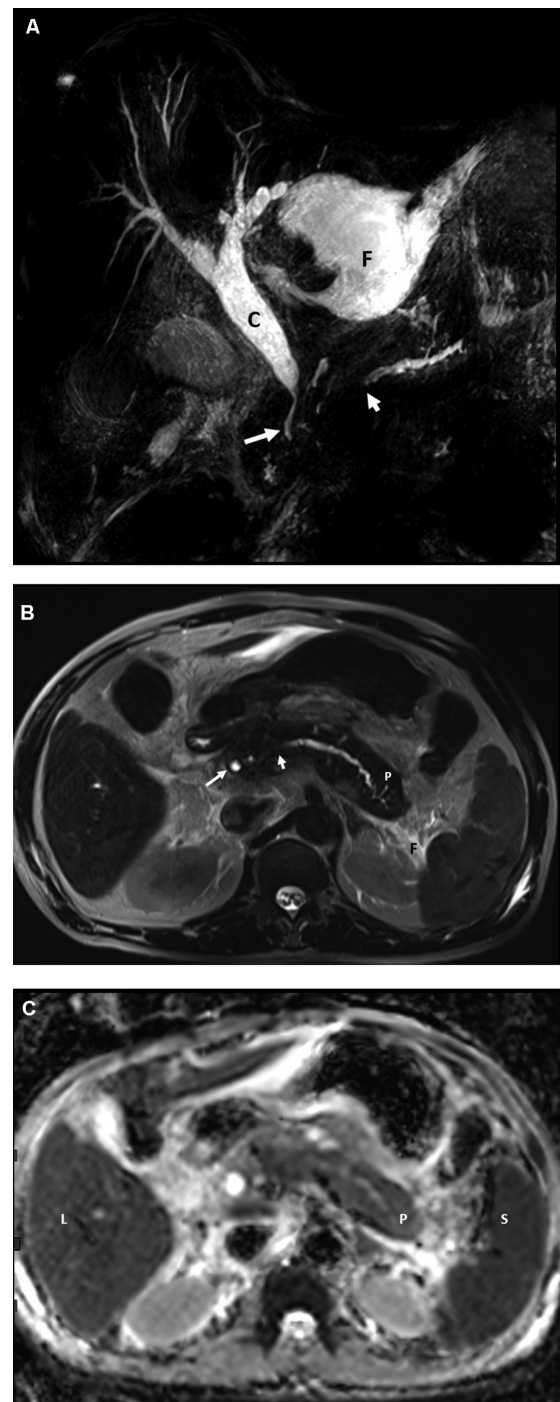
Magnetic resonance (MR) in a 47/M, showing acute on chronic alcohol-related pancreatitis with common bile duct (CBD) stricture. (A) Three-dimensional (3D) maximum intensity projection (MIP) magnetic resonance cholangiopancreatography (MRCP) shows dilated and tortuous pancreatic duct with abrupt cutoff in the body (small white arrow). The long white arrow is CBD stricture. C is CBD and F is fluid. (B) Two-dimensional (2D) thin MIP high-resolution T2-weighted (T2W) image shows a bulky pancreas (P). The pancreatic duct in the body and tail is dilated with an abrupt cutoff (small white arrow). The long white arrow is CBD. (C) Apparent diffusion coefficient (ADC) image in axial plane shows diffuse restriction of the parenchyma (P). S is spleen and L is liver.
